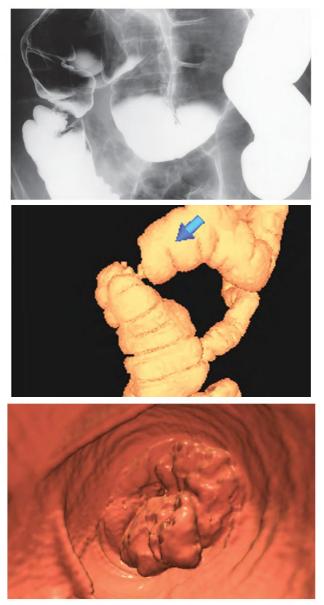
Iron-defi ciency anemia. A, Barium enema radiograph showing an annular filling defect (arrow) of the ascending colon due to adenocarcinoma. B, Virtual colonoscopy: annular ("apple-core") narrowing of the colon 126 cm from the anal verge. C, Luminal views reveal fungating adenocarcinoma (same case as B). (B and C, Courtesy of Dr. J. Bell.)⁽⁷⁾
